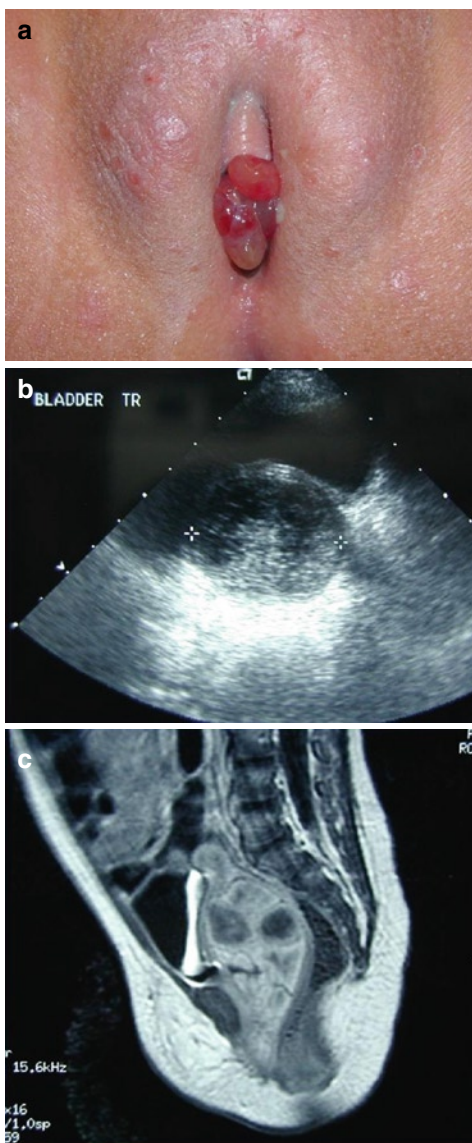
(a) Vaginal rhabdomyosarcoma: Fleshy grape-like clusters of tissue. (b, c): US and MRI of vaginal rhabdomyosarcoma.
